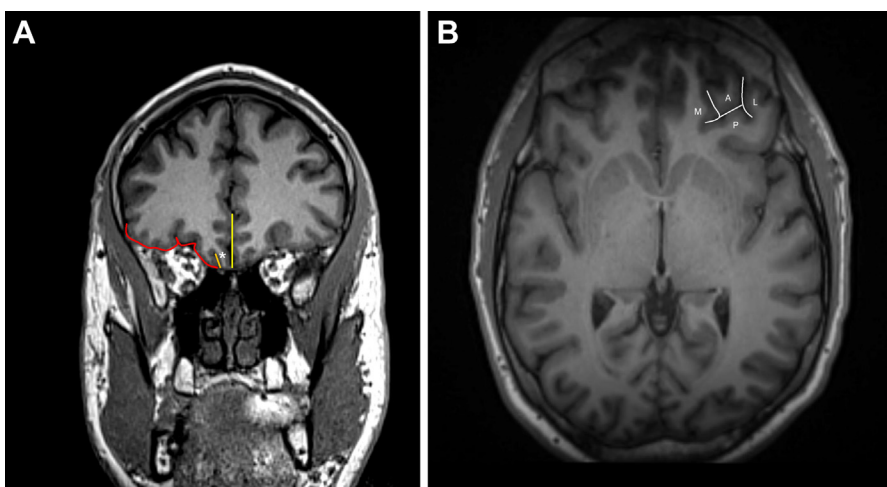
Coronal and axial T1-weighted magnetization-prepared gradient echo (MPRAGE) images through the level of the orbitofrontal cortex. (A) Far anterior coronal image shows the orbitofrontal cortex (*red outline*), which is separated from the gyrus rectus (*asterisk*) by the vertically oriented olfactory sulcus (*orange line*). The interhemispheric fissure is delineated as a yellow line dividing the cerebral hemispheres. (B) Axial image shows the H-shaped orbital sulcus separating the anterior (A), lateral (L), posterior (P), and medial (M) orbital gyri.
